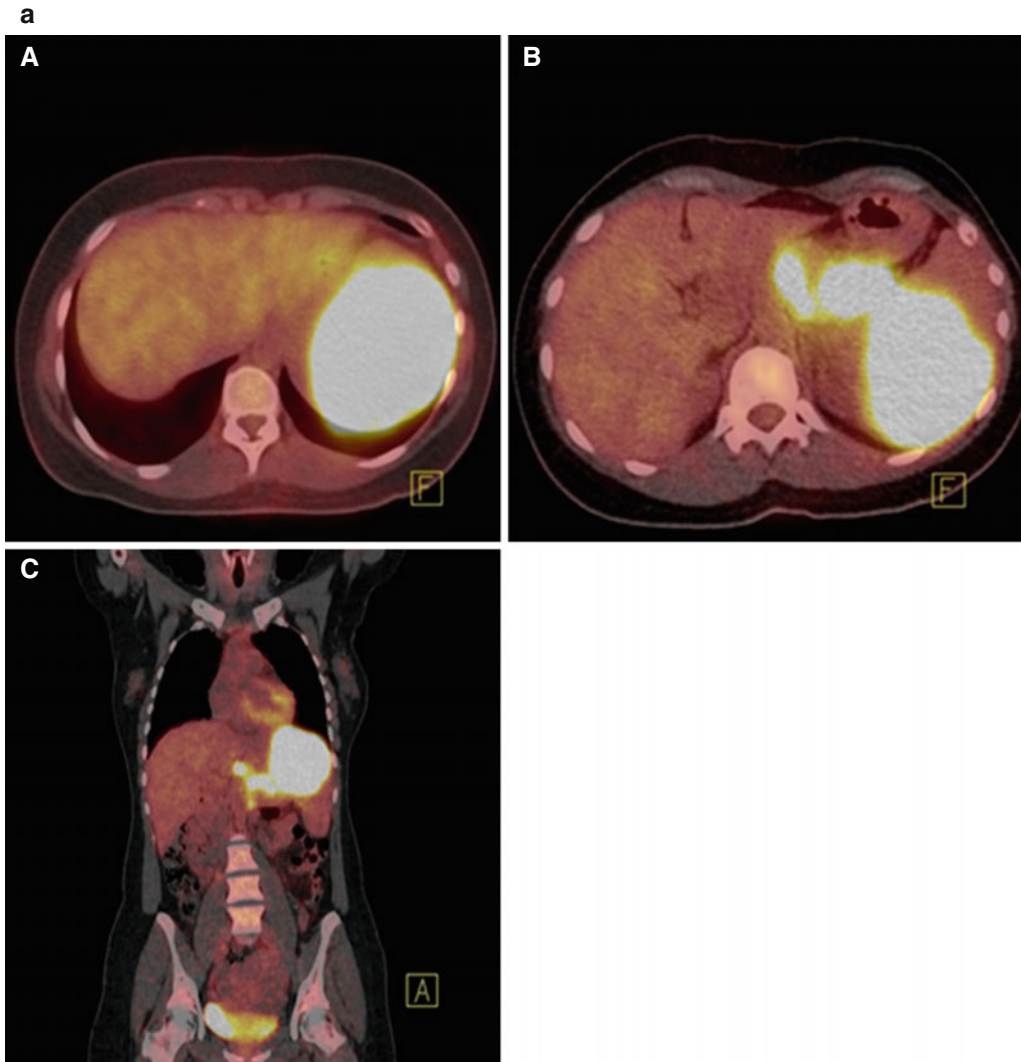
(a) Axial PET/CT images (A, B) show hypermetabolic lesion of the spleen (SUVmax 27.8) and hypermetabolic lymph nodes (SUVmax 21.4) in the abdomen. Coronal PET/CT image (C) shows the extent of the disease in the abdomen. (b) PET/CT study 7 months later
